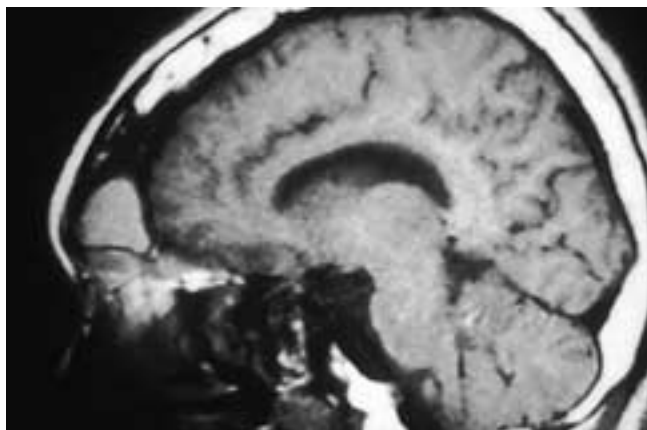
Sagittal T1-weighted MR image scan shows an expansile frontal sinus mass with an intermediate signal intensity. This mass had a high T2-weighted signal intensity. This patient had a frontal sinus mucocele.
